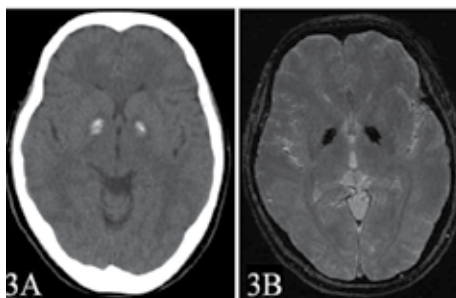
Computed tomography and gradient echo T2WI after carbon monoxide intoxication.
